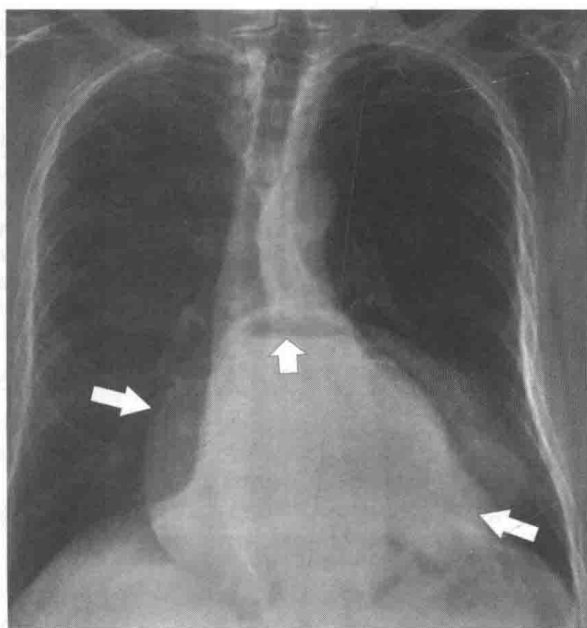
Chest radiograph in a 56-year-old man with a large hiatal hernia (*large arrows*) and gastric fluid level (*small arrow*). Most of the stomach resides in the chest.
